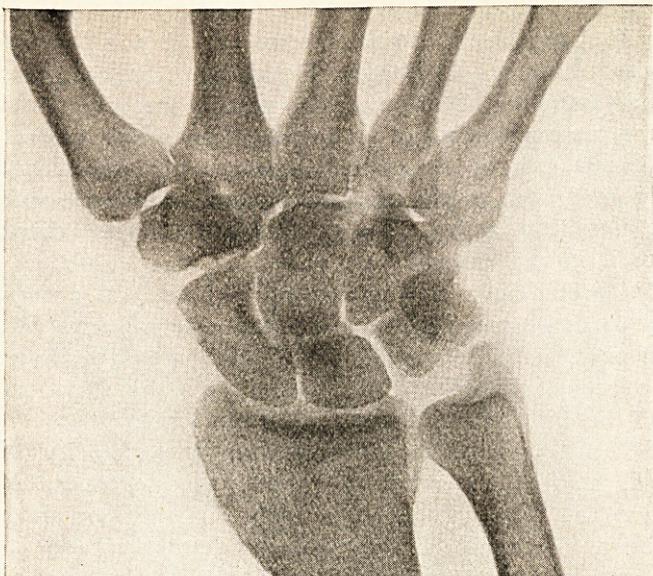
Case I. (P. R.). First X-ray of wrist, showing normal structure.
